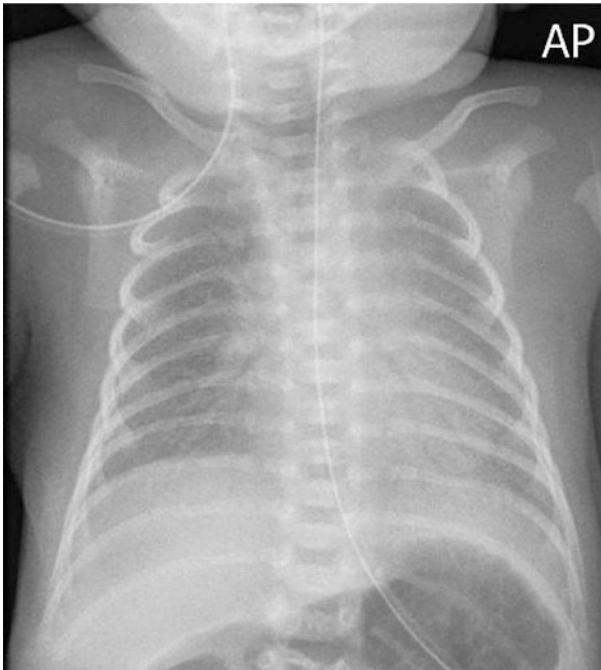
Chest radiograph in a premature neonate which shows small lung volumes and a hazy opacification throughout the lungs in keeping with RDS
